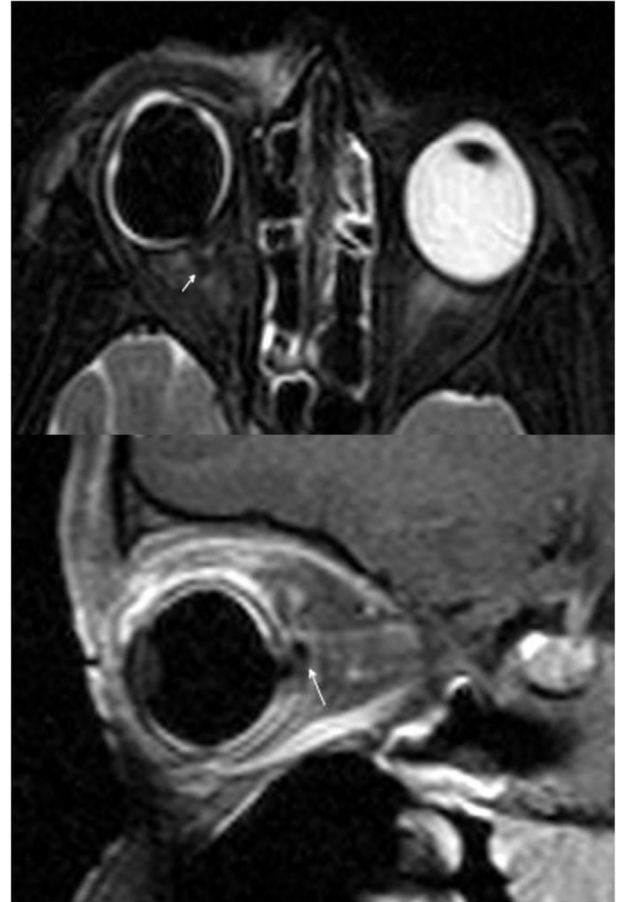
Axial T2 (upper section) and sagittal contrast enhanced fat suppressed T1 (lower section) magnetic resonance imaging demonstrates right optic nerve head excavation and suppression of the signal within the right globe and subarachnoid space in the retrobulbar area suggestive of perfluorocarbon liquid or silicone oil bubble (arrow).
